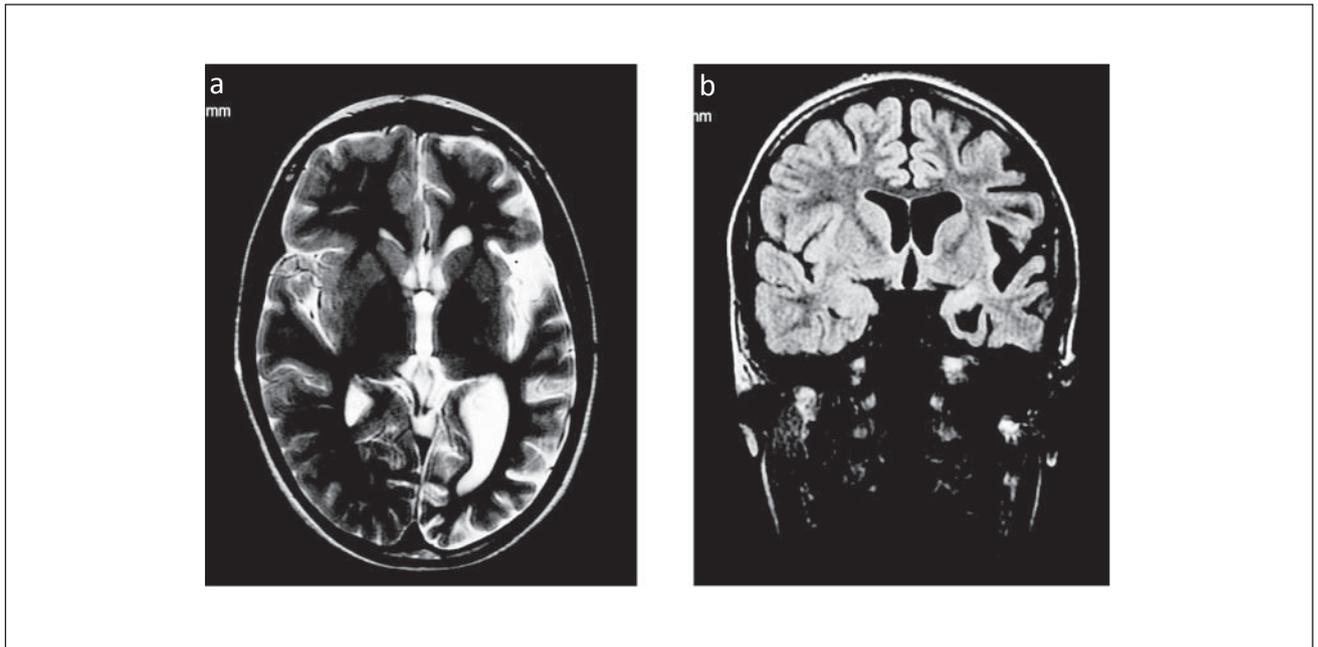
Brain MRI of the presented patient at the age of 8 years. The volume of the left cerebral hemisphere is decreased due to the cortico-subcortical atrophy – this is seen as the widening of the left lateral ventricle and of the pericerebral fluid spaces, in the region of the insula in particular. FSE/T2-weighted image, axial plane (a), FLAIR image, coronal plane (b).
